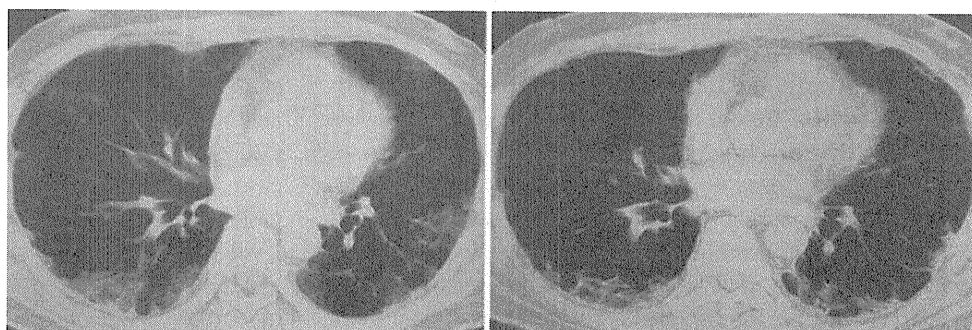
Changes in chest computed tomography (CT) findings in surviving patient 3. Extensive ground-glass opacity (GGO) and consolidation before starting therapy (*left*). Improved CT findings after six sessions of intravenously administered pulse cyclophosphamide (IVCY) therapy (*right*)
